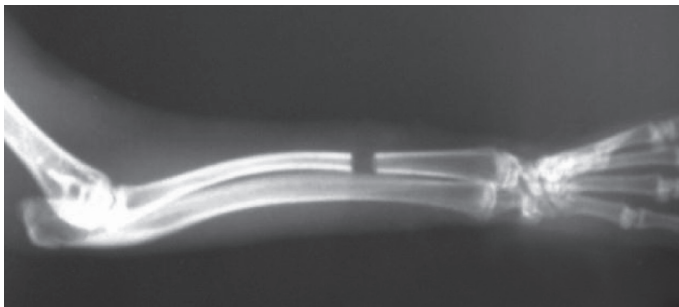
Lateral X-ray image of the operated forearm showing radius osteotomy.
